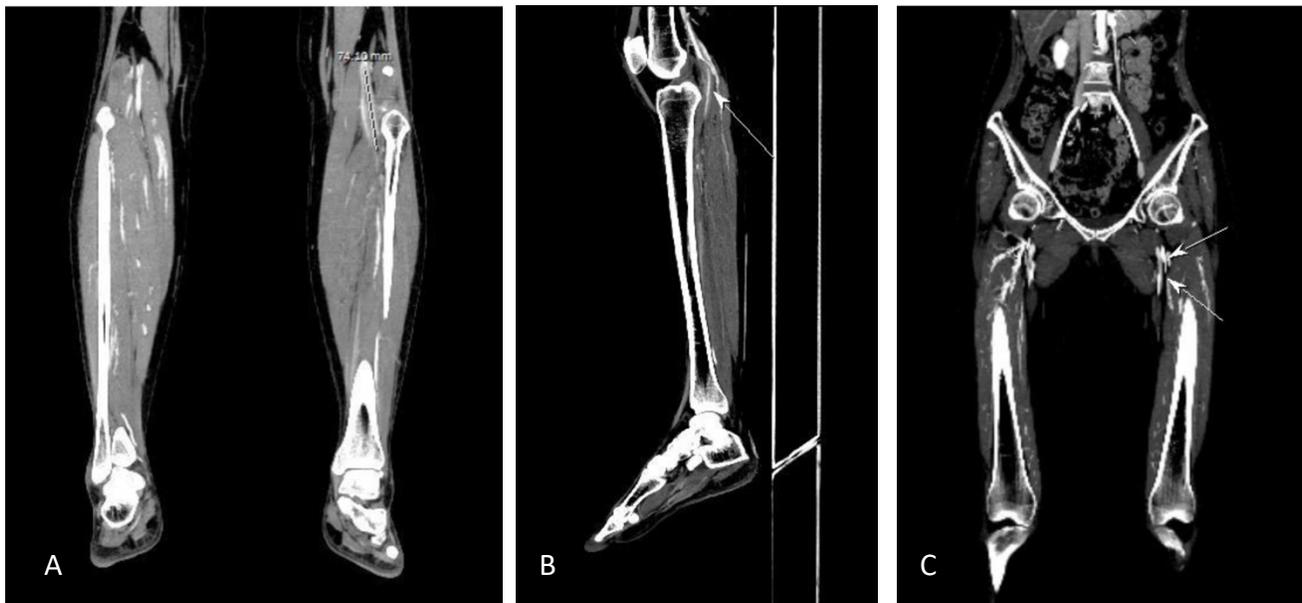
Computed tomography angiogram (CTA) shows thrombosis of left popliteal artery on coronal view (A), sagittal view (B) and thrombus in left common femoral vein (C).
